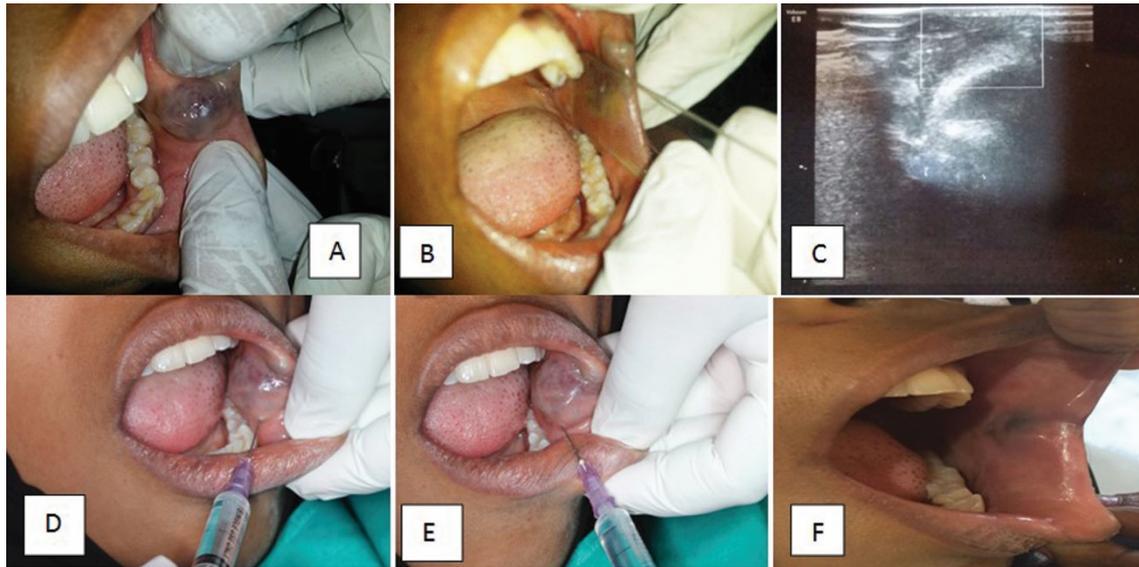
A-Intraoral Examination, B-Positive diascopy test C-Ultrasonography of the lesion, D-Intralesional injection of polidocanol, E-Intralesional injection of polidocanol in different direction, F-Regression of the lesion after follows up of one month
